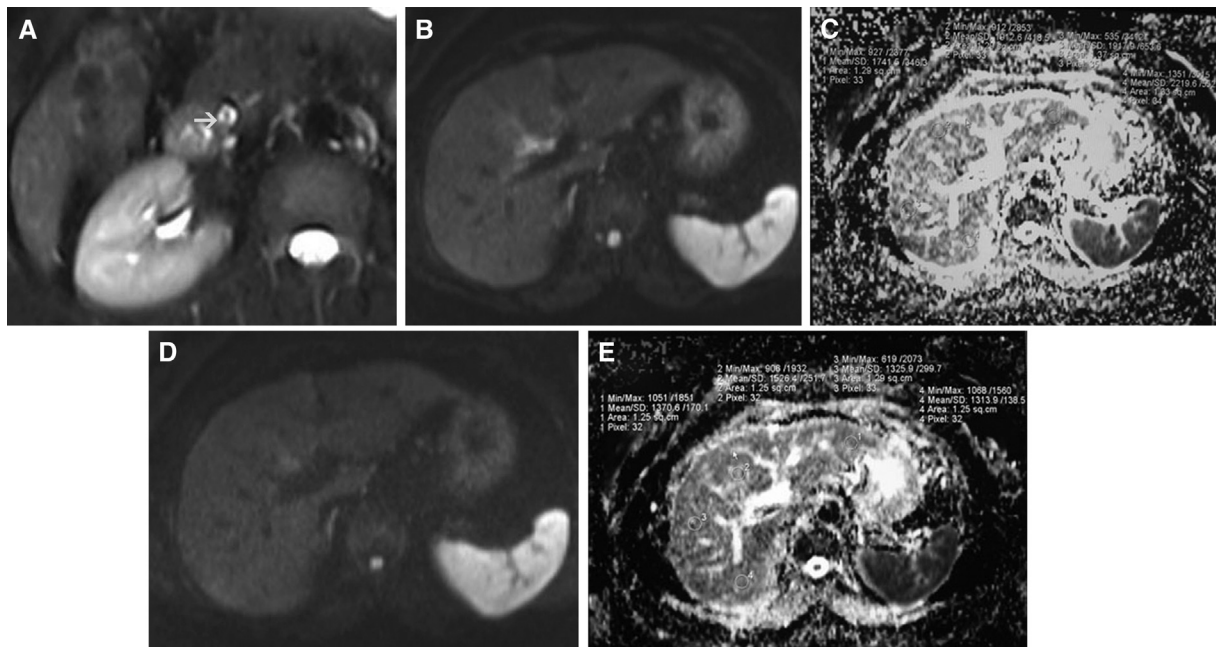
Bile duct stone in a 55-year-old-woman. (A) Axial T2-weighted magnetic resonance image shows distal calculus (arrow). (B) Diffusion-weighted image of the liver with a b-factor of 200 s/mm², the corresponding apparent diffusion coefficient (ADC) image of liver (C). The regions of interest are in the 4 segments of the liver. Minimum, maximum, and mean ADC values and standard deviations are seen. (D) Diffusion-weighted image of the liver with a b-factor of 600 s/mm², (E) the corresponding ADC image of the liver. The regions of interest are in the 4 segments of the liver. Minimum, maximum, and mean ADC values and standard deviations are seen.
